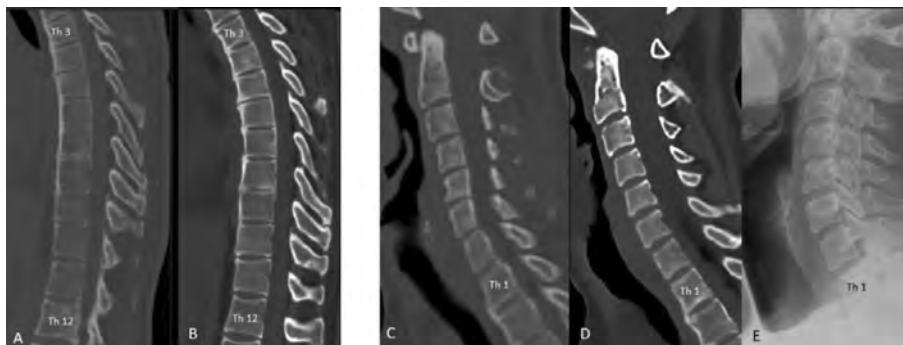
A-B: Low-dose CT (A) and MRI-based synthetic CT (sCT, B) of the thoracic spine. Ankylosis is seen anteriorly at several upper thoracic vertebral levels, with both modalities. C-E: Low-dose CT (C), sCT (D), and X-ray (E) of the cervical spine. Anterior ankylosis is seen at the Th1/Th2 level, both on low-dose CT and sCT, while this level is not visualized adequately by X-ray. Note: Low-dose CT versus sCT slice positioning (A-D) differ slightly at some levels. All images are from the same axSpA patient.
